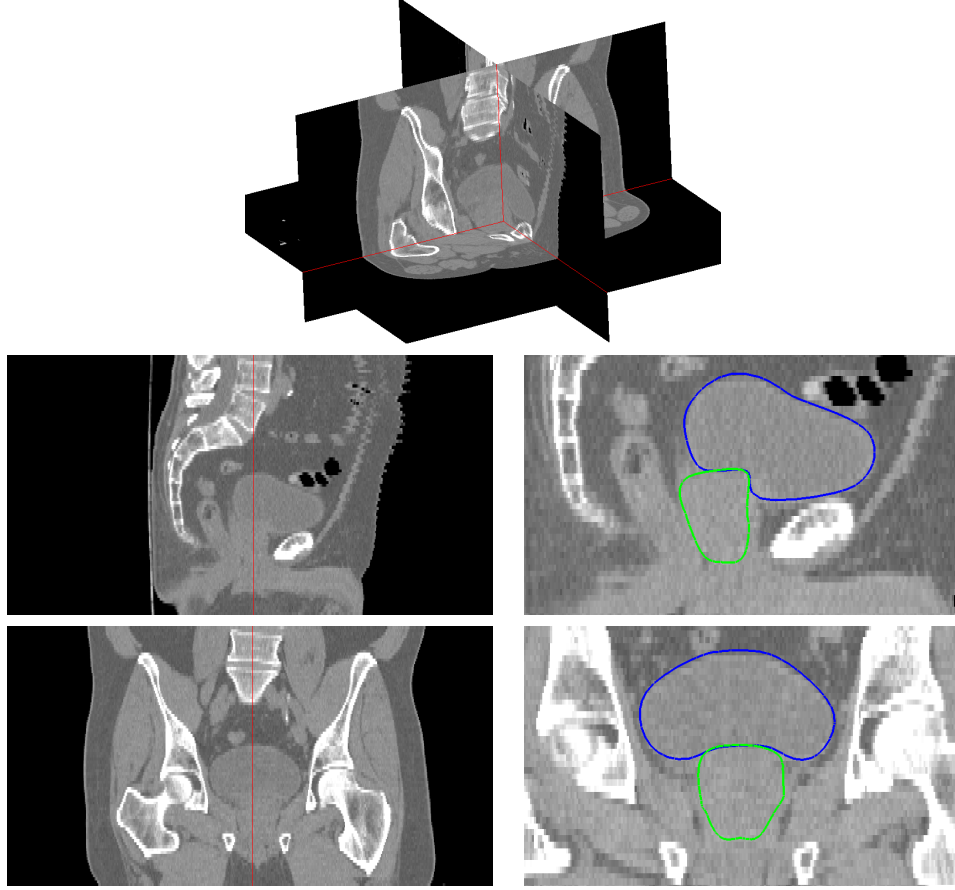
Top: Orthogonal slices of a 3D computed tomography (CT) image of the male pelvis, shown off-axis. Middle: Sagittal slice with bladder (blue) and prostate (green) segmentations. Bottom: Coronal view with corresponding segmentations. The red lines show the intersection of two orthogonal slices.
